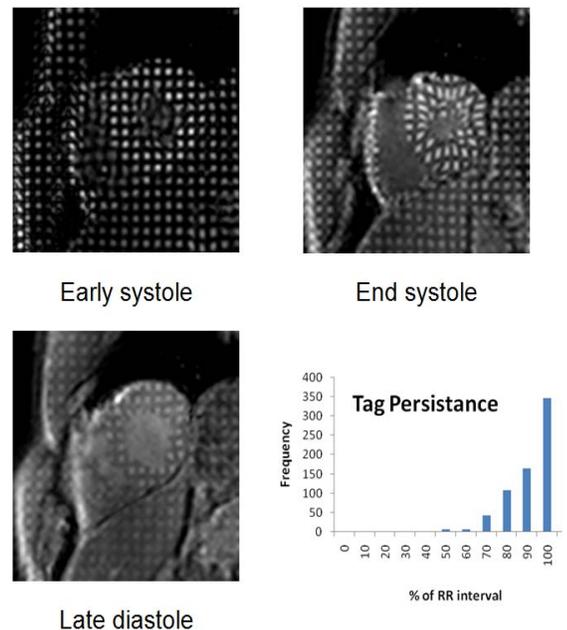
Short axis, tagged MRI images obtained in early systole, end systole and late diastole showing tag persistence. The histogram in the right lower panel shows that the most participants have tags which persist late in the cycle which will permit analysis of diastolic function.
